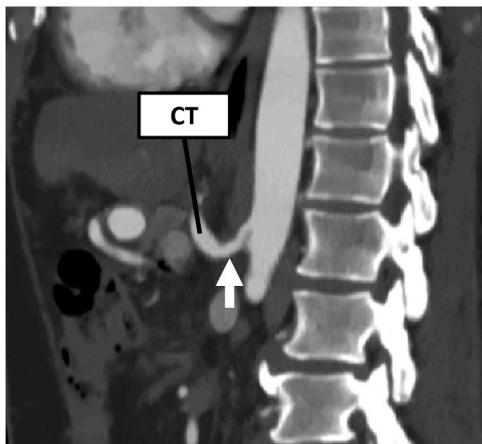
Arcuate ligament syndrome. Proximal celiac trunk (CT) stenosis with a hooked appearance (arrow), with post-stenotic dilatation.
